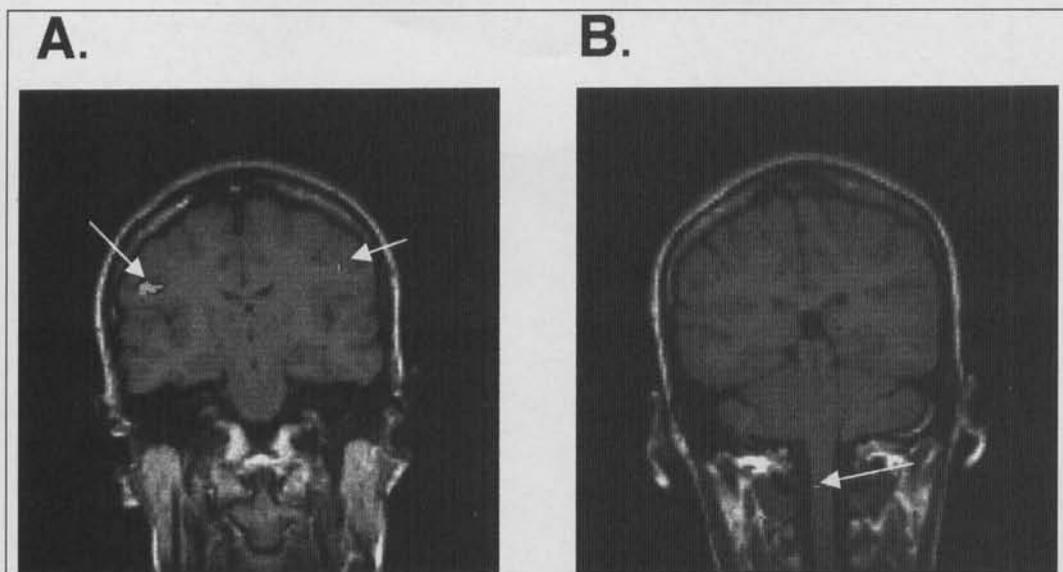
Brain activation maps overlaid to T1-weighted coronal magnetic resonance images (TR/TE; Nex = 450/14; 0.75) in a normal human volunteer. The maps show activation during a tongue-tapping task bilaterally in the primary motor cortex (A; arrow) and in the caudal hypoglossal nucleus (B; arrow). (Adapted from Mosier, 1998).
